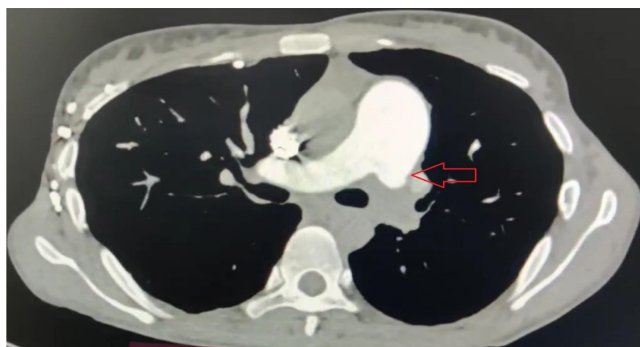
CT pulmonary angiography showing contrast cutoff in the left pulmonary artery (as in arrow).
